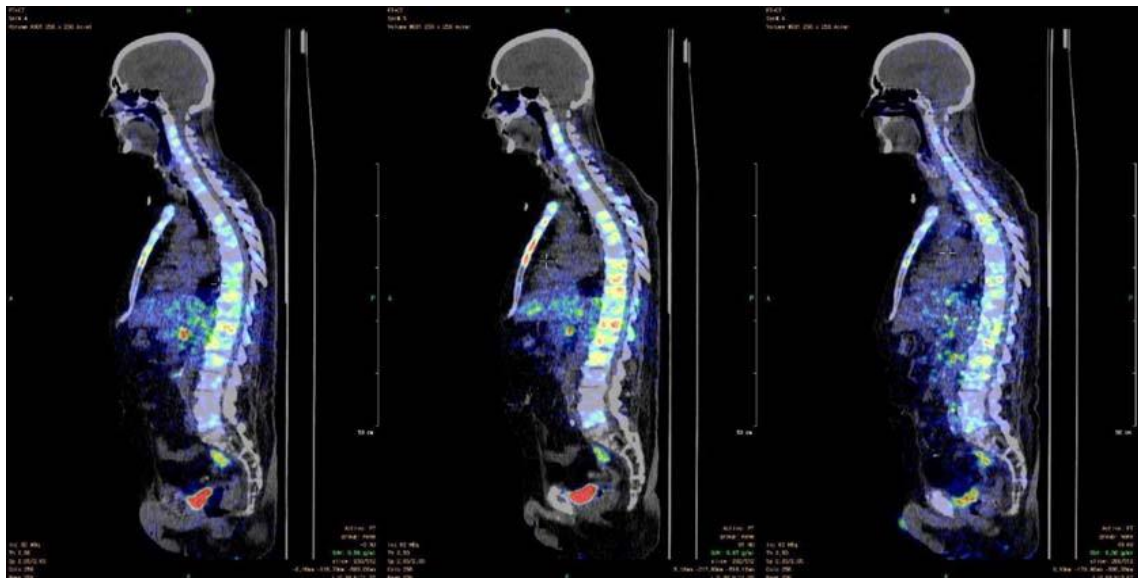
Distribution of $[^{44}\text{Sc}]\text{Sc-PSMA-617}$ at 45 minutes and 2 and 19.5 hours postinjection (from left to right).
